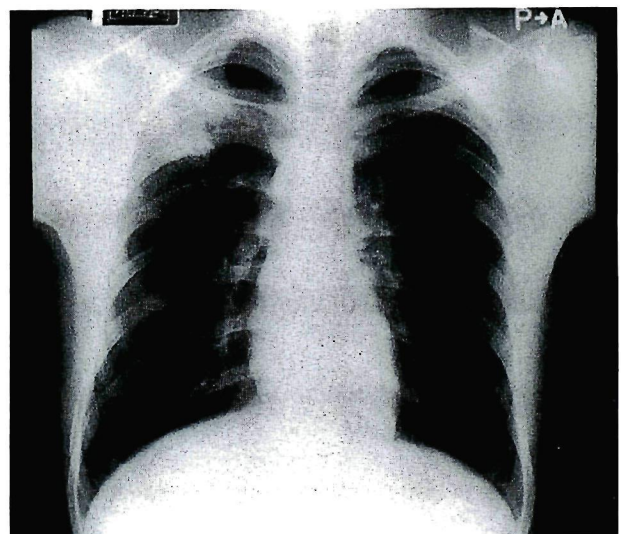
Chest x-ray of Case A (rIII1).
